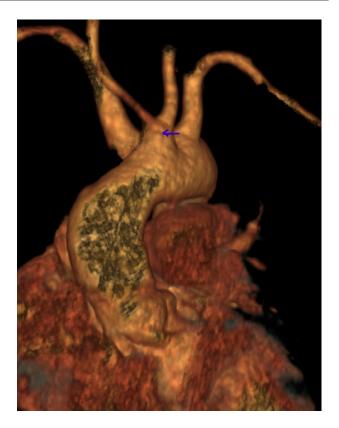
Anterior view of a CT angiogram with 3D reconstruction shows a common origin of bilateral carotid arteries (arising from the aortic arch who is called a truncus bicaroticus (blue arrow) associated with Arteria lusoria.
